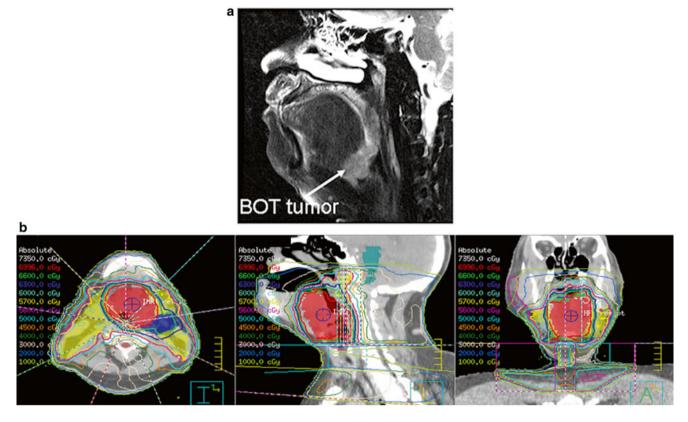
Base of tongue tumor. (a) Initial T2-weighted MRI appearance of a T3 N1 M0 base of tongue squamous cell carcinoma. (b) IMRT treatment plan for definitive chemoradiation of this lesion to a dose of 70 Gy in 33 fractions
